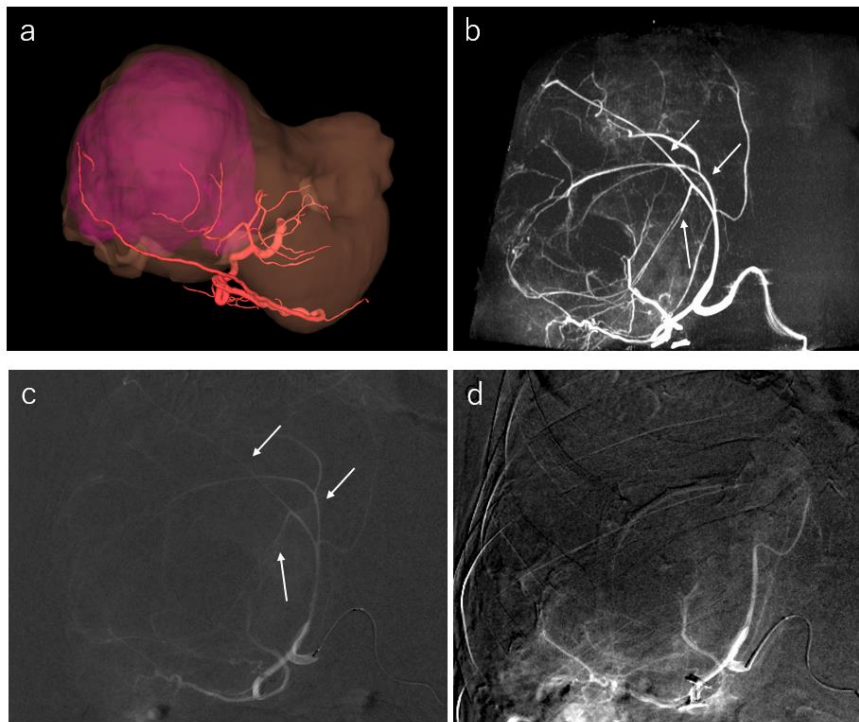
(a) The result of vascular image reconstruction using SYNAPSE VINCENT V5.5.0007 at second presentation. (b&c&d) The result of transcatheter arterial embolization. Note that there are no obvious extravasation nor pseudo-aneurysm. The anterior segment branches of the right hepatic artery, which corresponds to the extravasation shown in the CT scan (indicated by arrows in Fig. 3b&c), were embolized.
